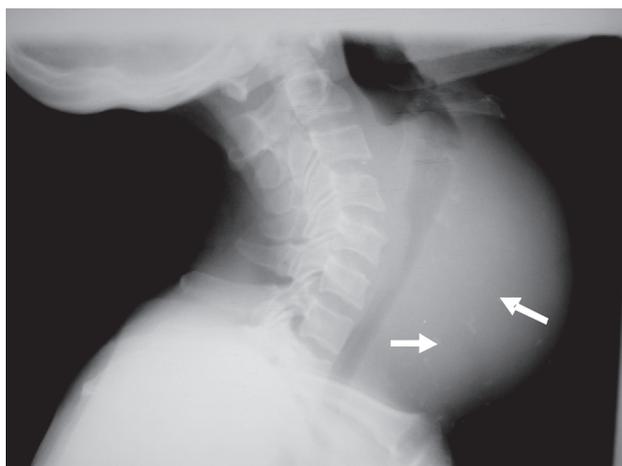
Anterior-posterior radiograph of soft tissue neck demonstrating huge anterior neck swelling involving the root of the neck, more towards the left with tracheal deviation to the right (arrows).
